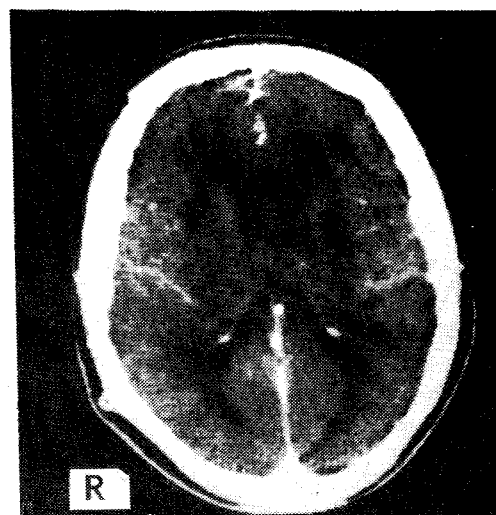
Patient 3: CT scan showing bilateral internal-capsule low densities, with the left more affected than the right.
